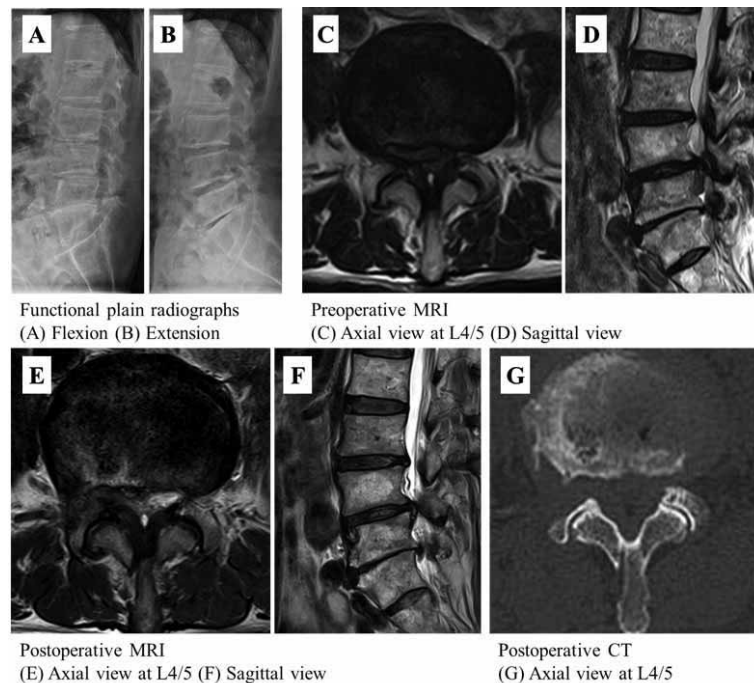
Case 1. Preoperative plain radiographs obtained in flexion (A) and extension (B) show mild segmental instability at L4/5 and disc narrowing at L5/S1. (C, D) Preoperative sagittal and axial MRI scans show a dorsally migrated herniated nucleus pulposus that is localized on the right posterolateral and a thickened ligamentum flavum at L4/5. (E, F) Postoperative sagittal and axial MRI scans confirm that the downward migrated herniated nucleus pulposus has been discectomized. (G) Postoperative axial CT scan at L4/5 confirms removal of the right superior articular process by foraminoplasty using a high-speed drill. 3D, 3-dimensional; MRI, magnetic resonance imaging; CT, computed tomography
